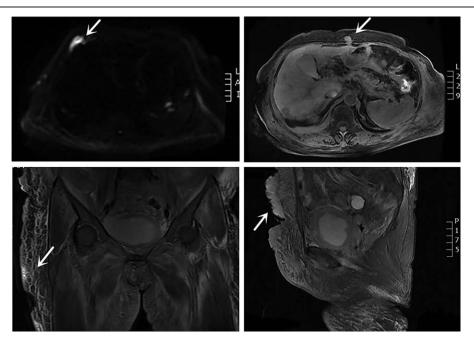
Magnetic resonance imaging (MRI) scan of the abdominal and pelvis shows multiple metastases in the abdominal wall and bilateral thigh skin, right costicartilage, and pelvic cavity (arrows). Lesions showed hyperintensity on diffusion-weighted imaging (DWI).
